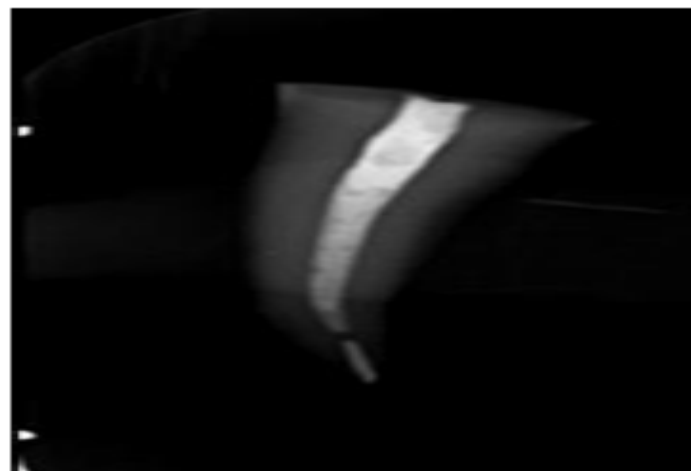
Radiographic image of root canal filling material over the broken file
